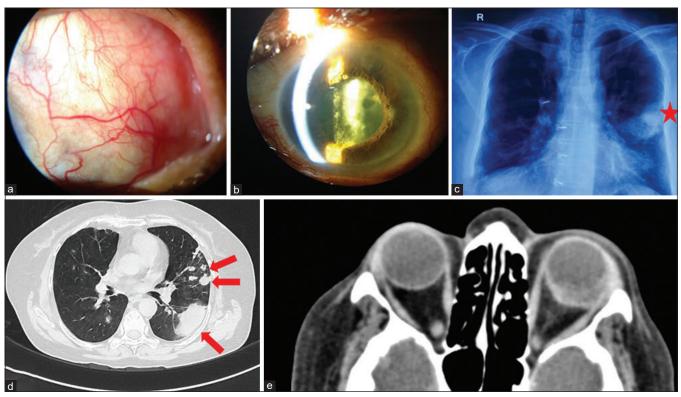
(a and b) Slit lamp examination of left eye showing congestion of deep episcleral and scleral vessels, and fluffy-fibrinous exudates around the lens. (c) Chest X-ray showing left lung mass/lucent round lesion (cavitary nodule, star). (d) CT chest showing multiple large nodules in both lungs. Left lung nodules are conglomerating to make a mass in posterior segment of left upper and lower lobes (arrows). (e) CT orbit showing left eye scleritis (posterior scleral thickening) with intravitreal/subretinal inflammatory collection
